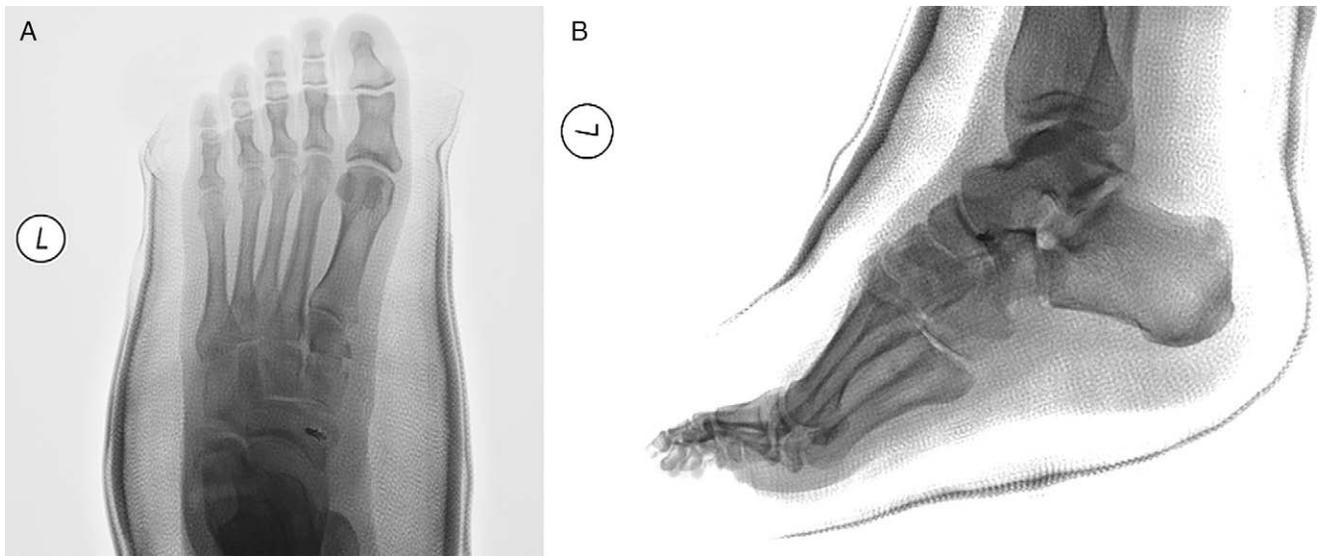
(A) Postoperative radiographs showing the centrally placed Cotton osteotomy and graft placement. (B) An Evans calcaneal osteotomy, flexor digitorum longus tendon transfer, and a tibialis posterior advancement were concomitantly performed.
